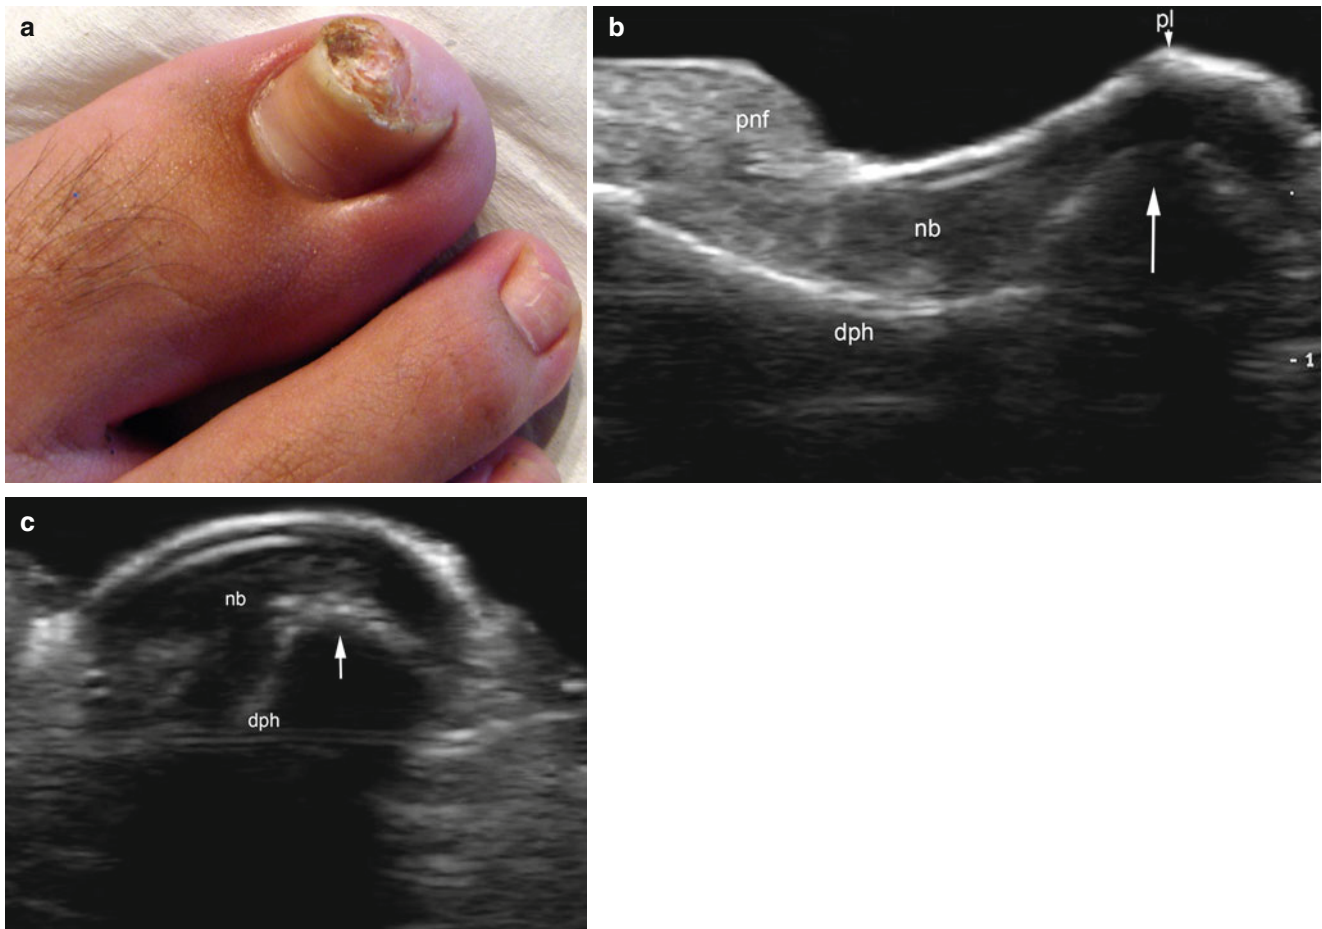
(a–c) Subungual exostosis. (a) Clinical image shows a brownish subungual lump in the nail of the right hallux. (b, c) Grey scale ultrasound images (b longitudinal view; c transverse view) show
